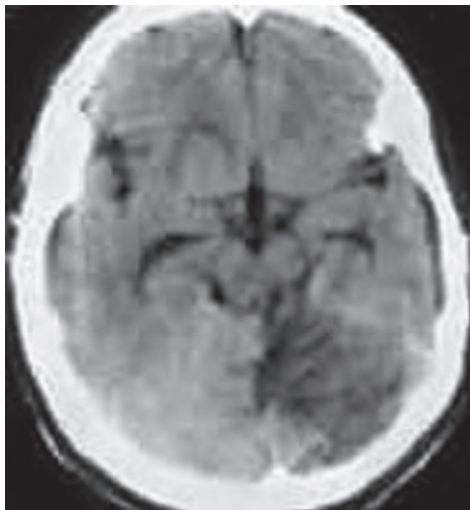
Cerebellar infarct-CT
